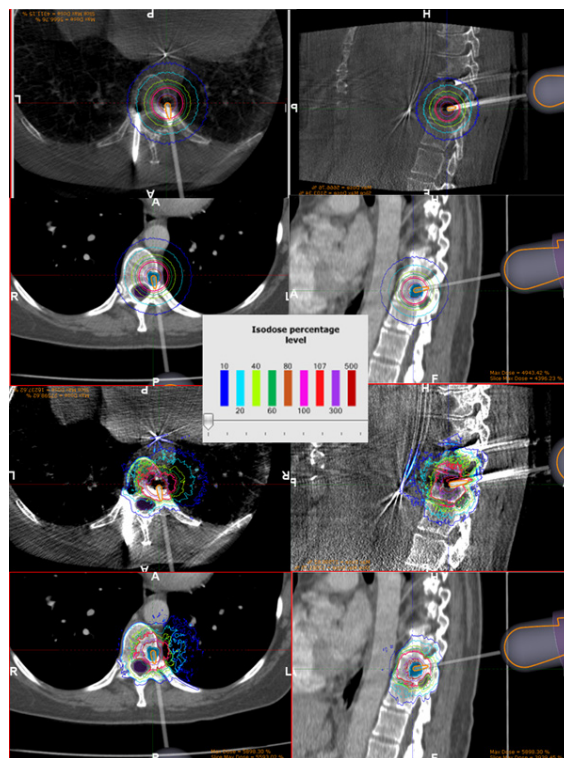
from top to bottom: dose distribution on CBCT (MCwater), pre-op CT (MCwater), CBCT (MChet), pre-op (MChet)
